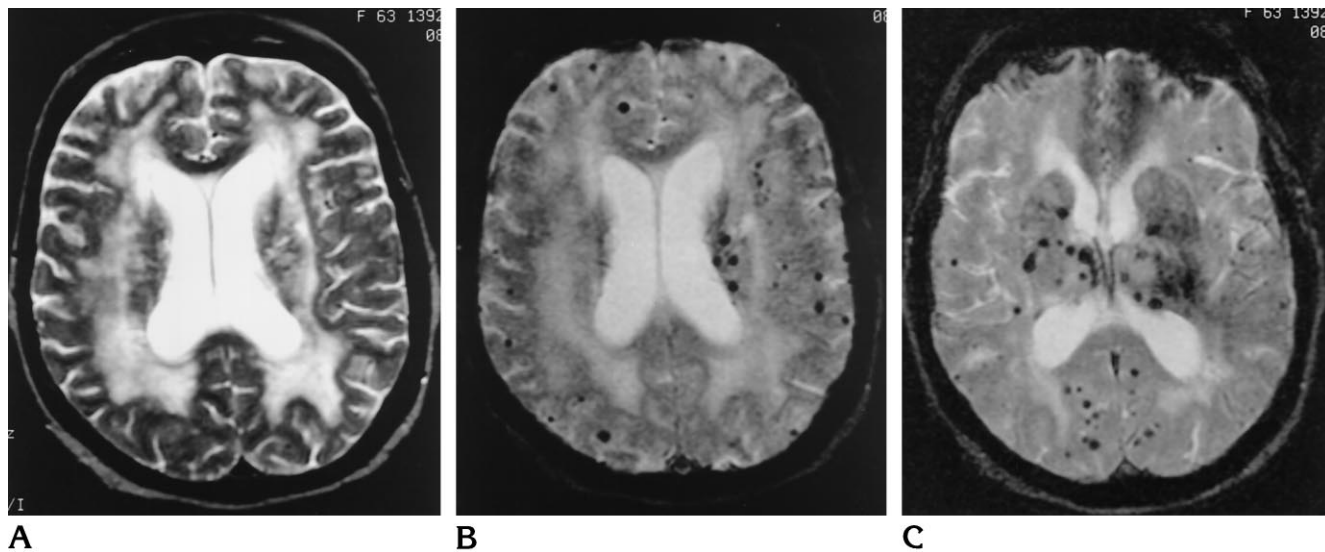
A, T2-weighted fast spin-echo MR image of a patient with chronic hypertension in whom progressively worsening dementia developed shows extensive white matter hyperintensity thought to represent severe leukoariosis. No hypointense lesion is identified clearly.
